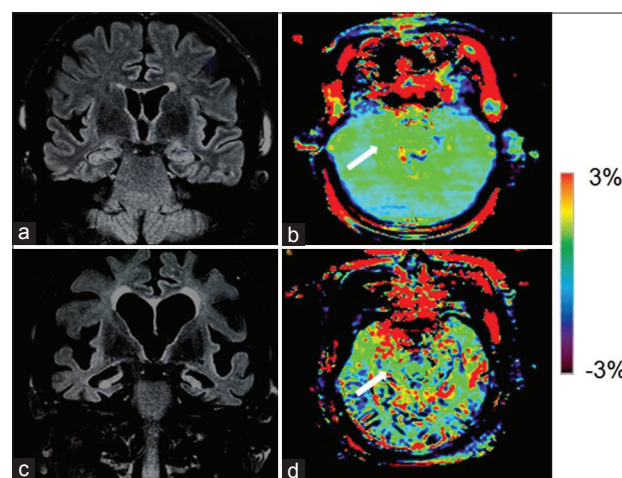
Fluid attenuated inversion recovery (FLAIR) image (a) and amide proton transfer (APT)-weighted image (b) of a typical normal control (female, 72 years old, mini-mental state examination [MMSE] score 29). FLAIR image (c) and APT image (d) of an Alzheimer's disease (AD) patient (female, 70 years old, MMSE score 16). Atrophy of bilateral hippocampi (Hc), enlarged lateral ventricles and widened sulci in AD were seen on the coronal FLAIR image. The APT-weighted intensities in regions of the Hc (white arrow) were higher in AD patients than in normal controls.
